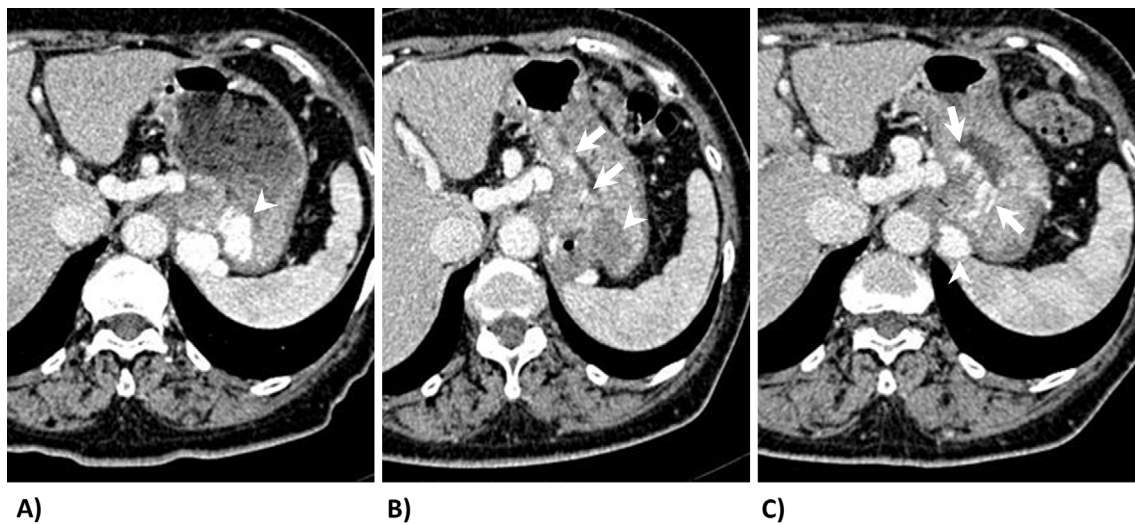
CECT images from before and after B-RTO. A) Before B-RTO, a gastric varix is evident in the cardia to the fornix (white arrowhead). B) At two weeks after B-RTO, fine blood vessels (white arrows) are seen surrounding the occluded varix (white arrowhead). C) At 23 months after B-RTO, fine blood vessels (white arrows) surround the occluded varix even more prominently. The GR shunt is preserved (white arrowhead). CECT: contrast-enhanced computed tomography, B-RTO: balloon-occluded retrograde transvenous obliteration, GR: gastrorenal
